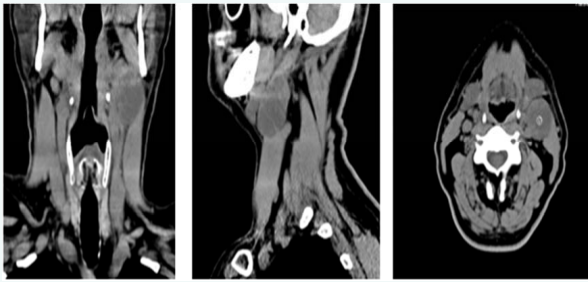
CT images of the soft tissues of the neck (coronal, axial and sagittal views).
